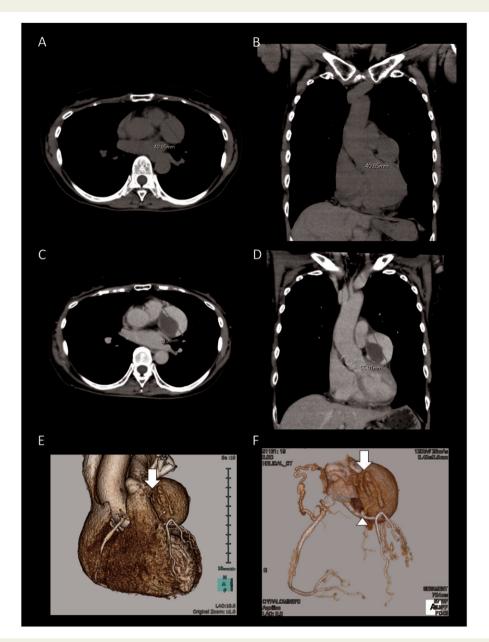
(A, B) Unenhanced computed tomography scan taken 2 years earlier showing a 4-cm mass. (C, D) Contrast-enhanced computed tomography angiography revealing a giant coronary aneurysm ($48 \times 45 \times 55$ mm) with internal contrast enhancement and thrombus formation. (E, F) Three-dimensional heart reconstruction of computed tomography images. Location of the aneurysm in the fistula originating at the mid-portion of left anterior descending artery (F arrowhead). The aneurysm branched into a tortuous vessel that connected to the main pulmonary artery (F, arrow). Another fistula from the proximal portion of the right coronary artery drained into the left atrium and the main pulmonary artery (F).
